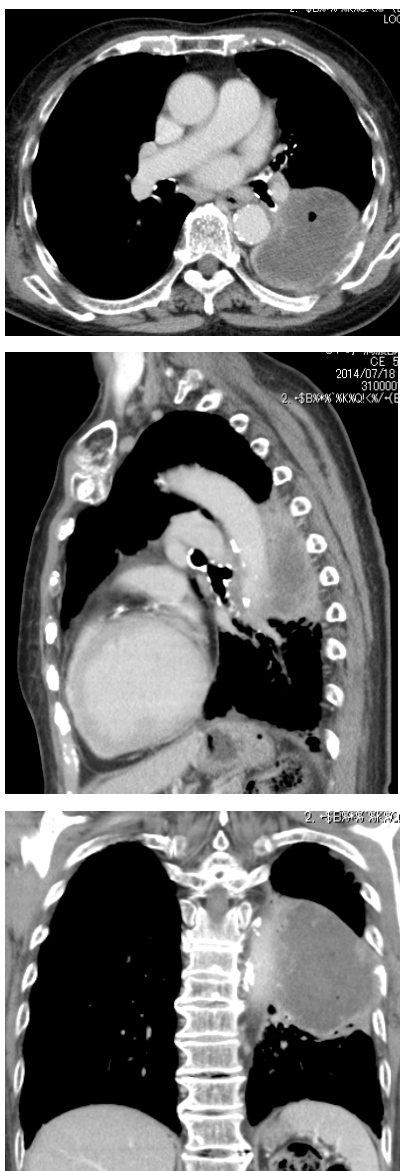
Computed Tomography Findings
